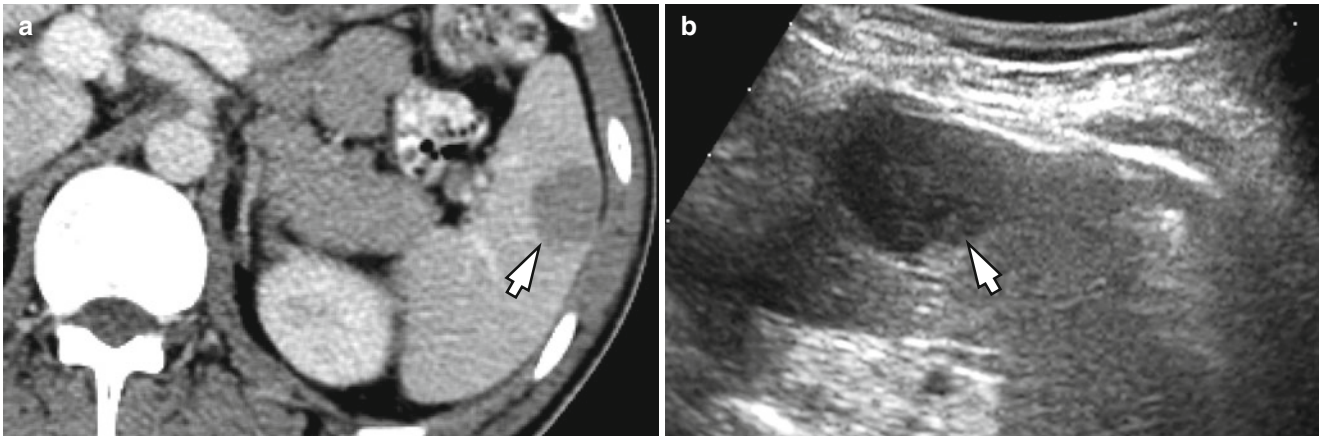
Splenic metastasis of nasopharyngeal carcinoma in a 37-year-old male. (a) Contrast-enhanced transverse CT image shows a 2.5 cm hypoattenuating mass (*arrow*) in the spleen. (b) On grayscale US, the lesion appears as a hypoechoic lesion (*arrow*)
